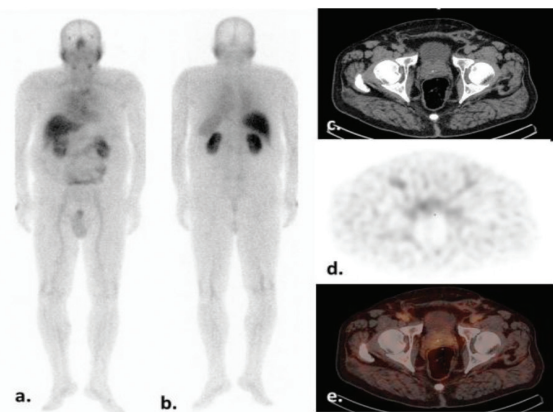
99m-Tc PSMA-ltS single photon emission computerized tomography imaging of 63 years old primary prostate cancer patient
